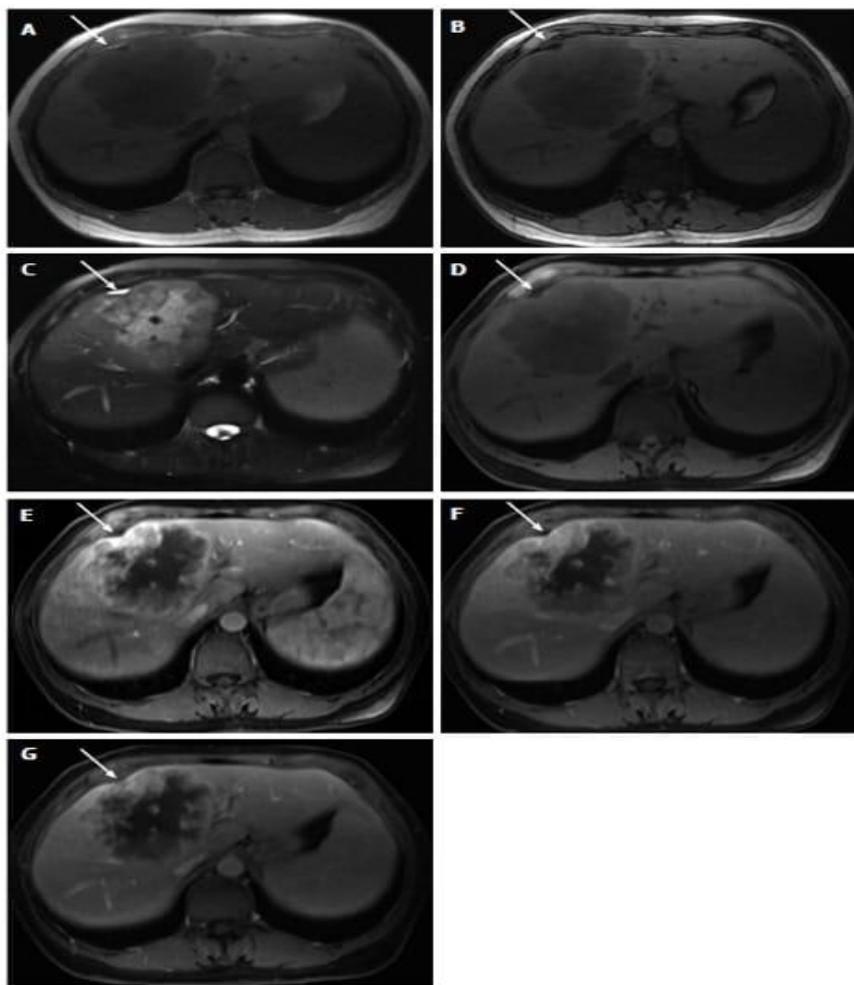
Intrahepatic cholangiocarcinoma. In- (A) and opposed-phase (B) GRE T1-WI, fat-suppressed FSE T2-WI (C), pre (D) and postcontrast fat-suppressed 3D-GRE T1-WI at the arterial (E), portal venous (F) and interstitial (G) phases. The tumor shows low signal intensity on T1-WI (A, B and D), high signal intensity on T2-WI (C), and heterogeneous peripheral continuous and progressive enhancement on post-gadolinium images (E-G). Associated capsular retraction is also noted (white arrow, A-G). GRE: Gradient-echo; FSE: Fast spin echo; T1-WI: T1-weighted images
